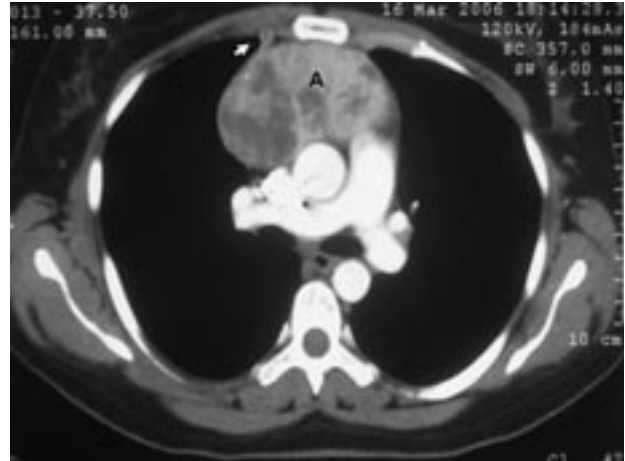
Chest CT scan showing a non homogeneous oval mass (A) in the anterior mediastinum and blood supply from thoracic vessels (arrow).
